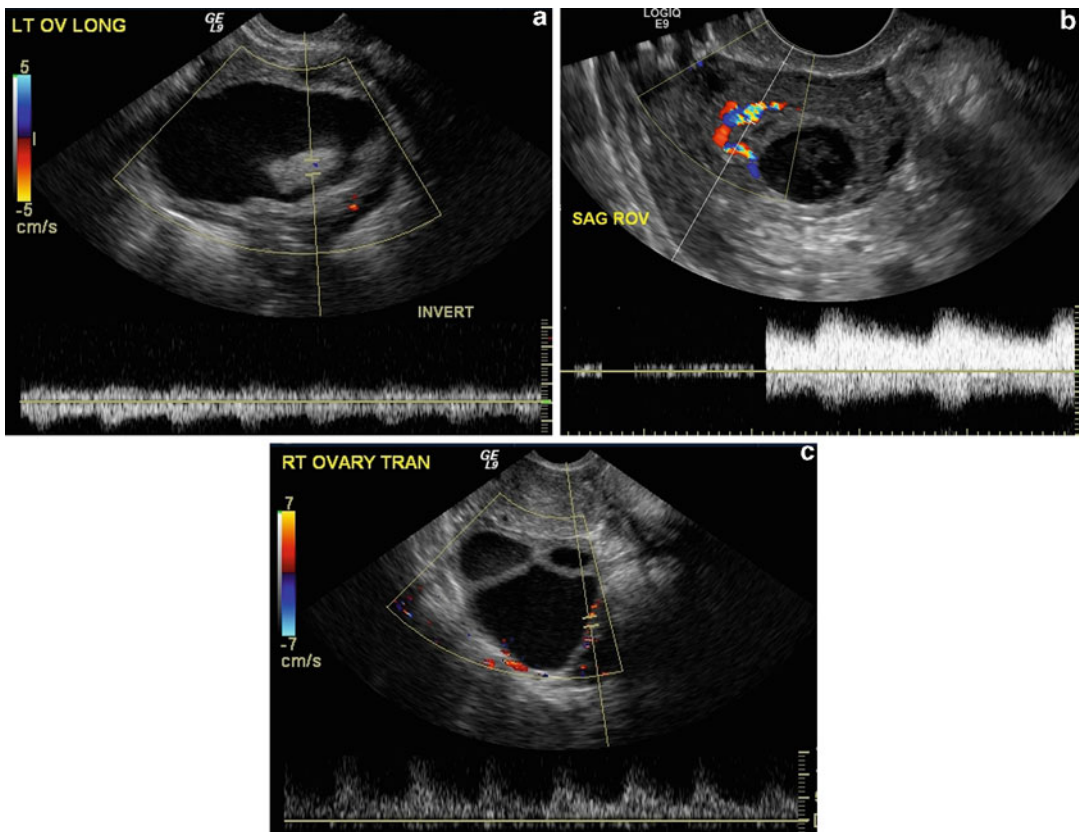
Spectral Doppler pattern of adnexal masses. (a) Low resistance arterial flow pattern in a malignant ovarian tumor. (b) Low resistance arterial flow pattern in a physiologic corpus luteum. (c) High resistance arterial flow pattern in an endometrioma
